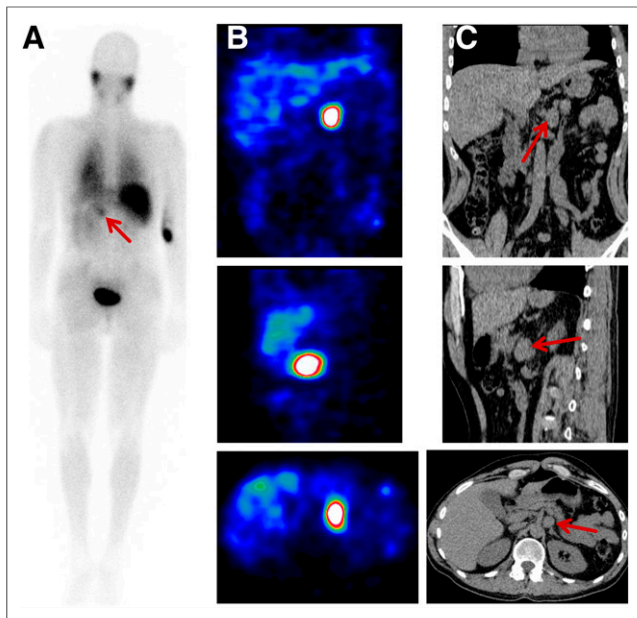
^{123}I -MIBG scintigraphy scans of 50-y-old male patient with *RET* mutation and pheochromocytoma on left side (indicated by arrow). (A) Planar-whole-body scan. (B) SPECT scan. (C) CT scan.
